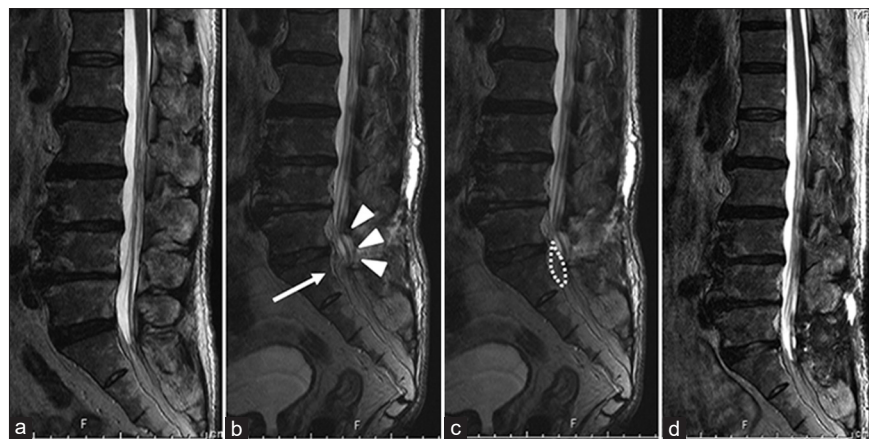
Magnetic resonance images of Case 4 (a) the dural sac terminated at S1 level. (b and c) Postoperative MR images revealed ventral compression of dural sac (white arrow heads) due to the engorged ventral epidural venous plexus (a white arrow and dotted line). (d) After laminoplasty and coagulation of the ventral epidural venous plexus, the dural sac ventral compression was relieved.
